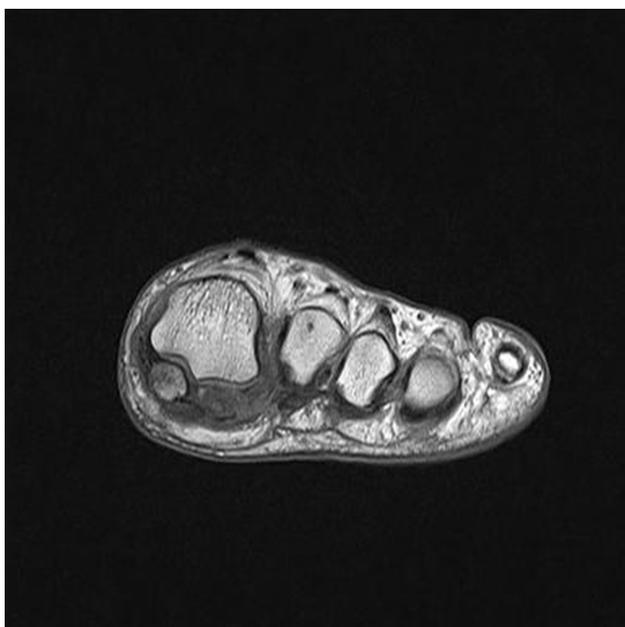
High-resolution CT of axial view of the foot.
